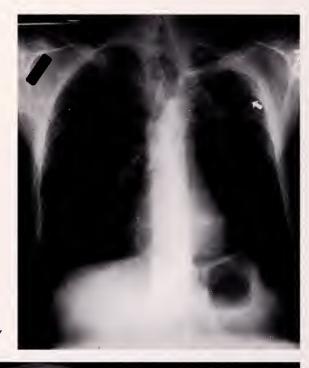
PA chest radiograph documenting a large thick walled cavity in the left upper lobe.
